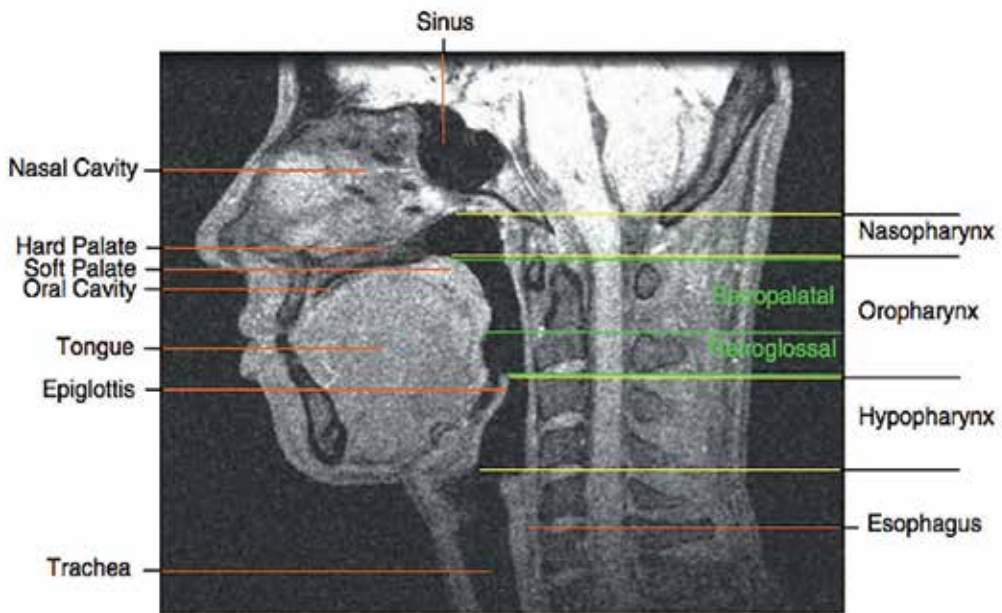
Sagittal magnetic resonance imaging of airway and division of oropharynx. (Clete A. Kushida)
